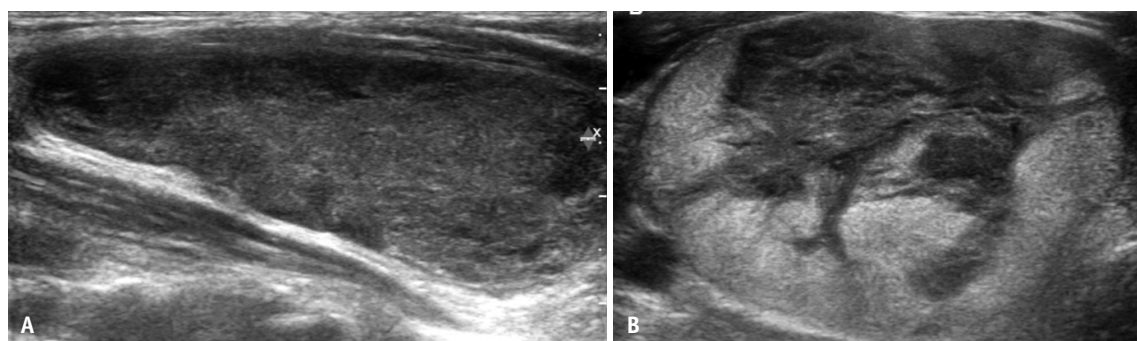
US images in patients with encapsulated angioinvasive follicular thyroid carcinoma. A: Longitudinal US image of a 60-year-old female with wild type TERT showing a 4.7 cm solid nodule with a smooth margin, marked hypoechogenicity, heterogeneous echogenicity, and parallel orientation. This nodule was classified as K-TIRADS category 4 and ACR-TIRADS category 4. After surgery, the TNM stage was classified as II (T3aN0M0) and there was no recurrence during 7 years of follow-up. B: Transverse US image in a 64-year-old female with mutant TERT showing a 3.4 cm solid nodule with a smooth margin, marked hypoechogenicity, heterogeneous echogenicity, and parallel orientation. This nodule was classified as K-TIRADS category 4 and ACR-TIRADS category 4. After surgery, the TNM stage was categorized as II (T3aN0M0) and there was no recurrence during 3 years of follow-up. US = ultrasound, TERT = telomerase reverse transcriptase, K-TIRADS = Korean-Thyroid Imaging Reporting and Data System, ACR = American College of Radiology, TNM = tumor, node, metastasis
